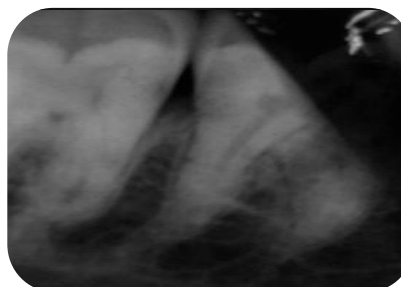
Periapical Radiolucency
